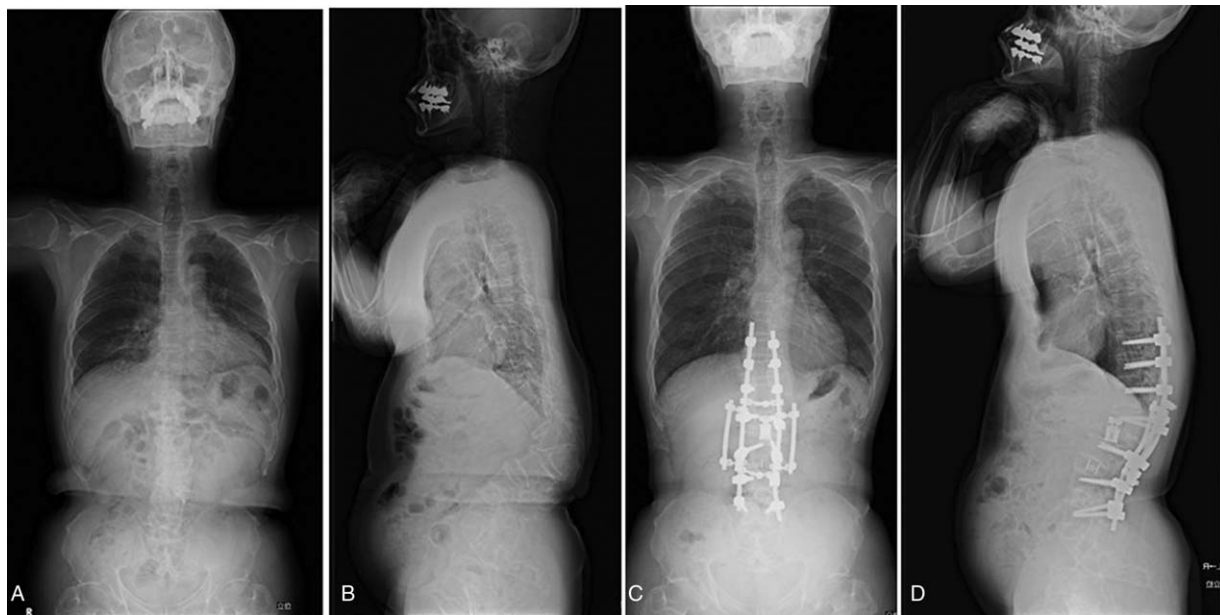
Preoperative and postoperative and lateral radiographs of the whole spine. Preoperative anteroposterior radiographs. Preoperative lateral radiographs show the apex at L2 and severe thoracolumbar kyphosis (105° , L1–L3). Postoperative anteroposterior radiographs. Postoperative lateral radiographs show the kyphosis corrected to 32° and nonpathologic sagittal balance of entire spine.
